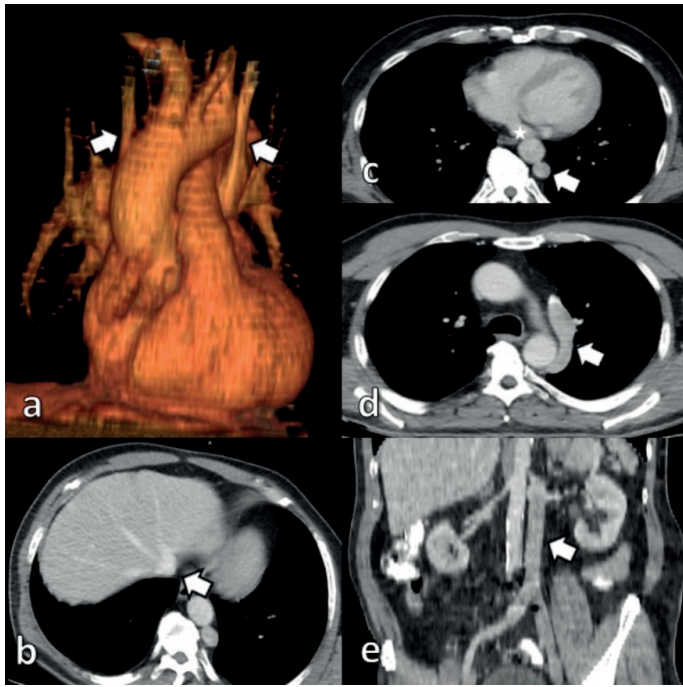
(a) 3D reformat image reveals double superior vena cava (white arrows). (b) The intrahepatic IVC is intact and the hepatic veins drain into the hepatic segment of the IVC (white arrow) on axial CT image. On coronal reformat CT image (e), infrarenal left IVC is intact (white arrow), whereas the suprarenal portion of the IVC is absent. (c, d) Left IVC continues by the help of left azygos vein (white arrows). There is anastomotic vein (white star) between the left superior vena cava and the right atrium through the coronary sinus.
